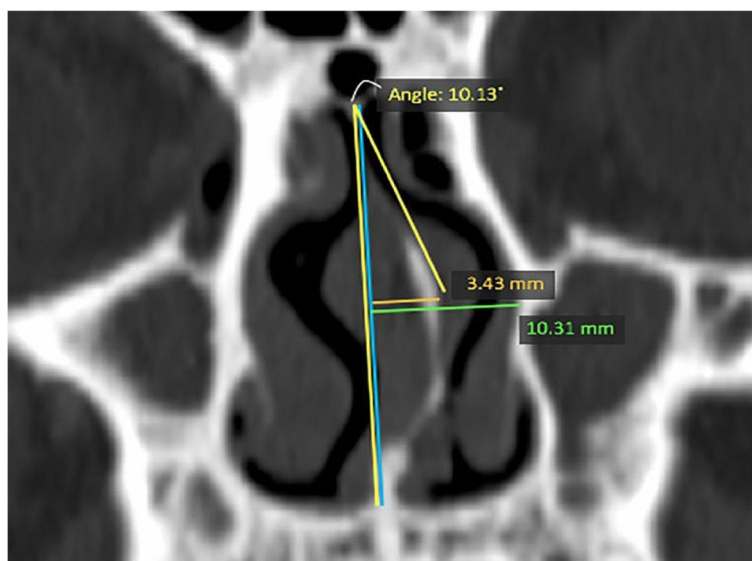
Computed tomography of the sinuses depicts a large magnitude of anterior septal deviation. The following measures were taken with regard to the midline (blue): septal deviation distance (SDD; orange), distance to lateral nasal wall (LNW; green), and septal deviation angle (SDA; yellow). This example computed tomography of the sinuses depicts a large magnitude of anterior septal deviation
